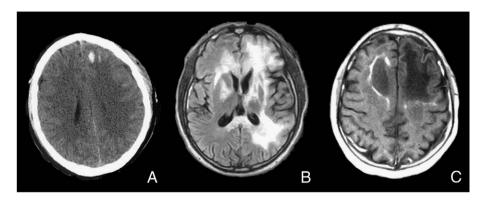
A. Patient 1. CT scan at the time of injury demonstrates a small contusion in the left frontal lobe. B. Patient 1. FLAIR image of slightly lower cut of cerebrum twenty-four months after the injury exhibits a diffuse high signal abnormality of left frontal lobe with some extension across the midline. C. Patient 1. T1-MRI at twenty-four months after the injury reveals contrast enhancement at the edge, particularly on the right, a neuroradiological hallmark of the advancing edge of demyelination in ALD.
